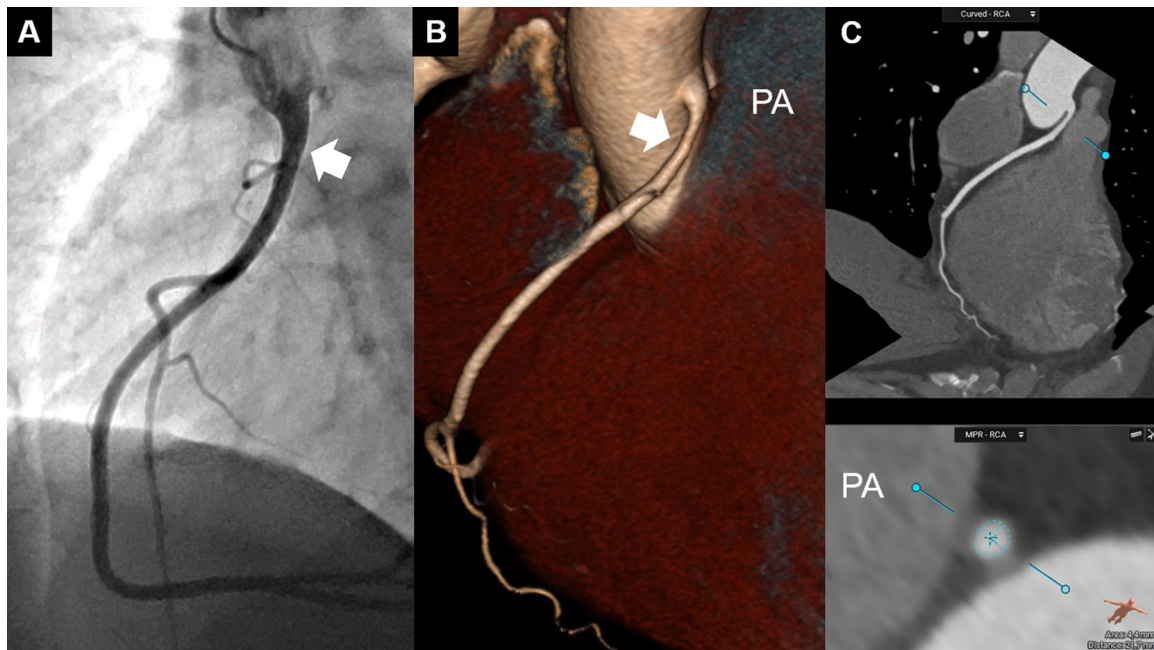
Anomalous right coronary artery with high take-off. (A) Angiographic image (right anterior oblique view) and computed tomographic images showing an anomalous right coronary artery (white arrow) arising from the ascending aorta (high take-off) without interarterial course. (B) Volume rendering view. (C) Multiplanar reconstructed views. PA, pulmonary artery. [Color figure can be viewed at wileyonlinelibrary.com]
